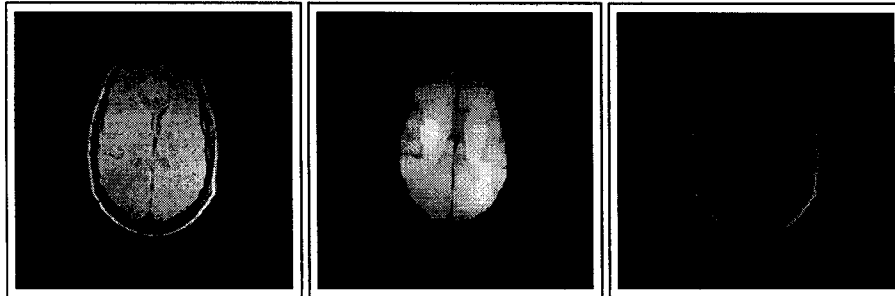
Example of opening (middle) and closing (right) by a square structuring element on a grey valued MR image (left).
